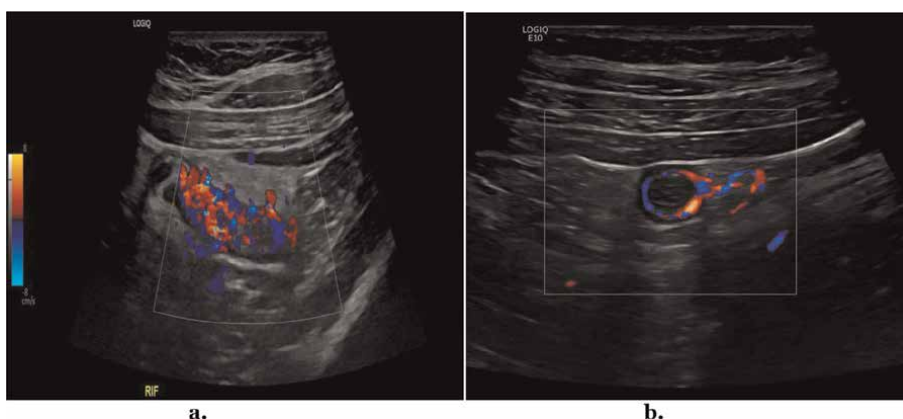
Sonograms acquired from different patients showing hypervascularity in uncomplicated appendicitis. A: Shows an inflamed appendix in a longitudinal orientation with significantly increased vascularity affecting roughly all the layers of the appendix; note the low PRF setting on the colour scale to the left of the image. b: Shows a transverse cross-section of the fundus of a focally inflamed appendix; note that the increased vascularity seen affects only the submucosa layer of the wall of the appendix (same patient as in Figure 5).
